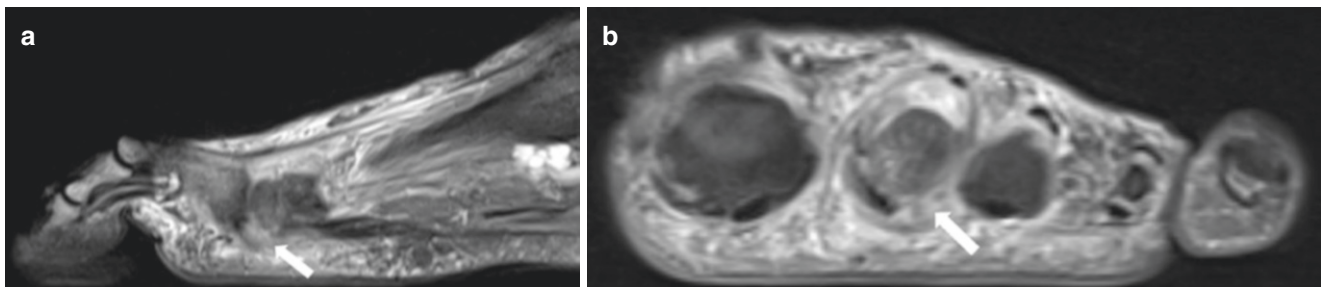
Plantar plate tear (lesser toes). Sagittal (a) and coronal (b) fat-suppressed T2-weighted MR images of the left forefoot demonstrate tearing of the second metatarsophalangeal plantar plate along its lateral aspect (*white arrows*)
